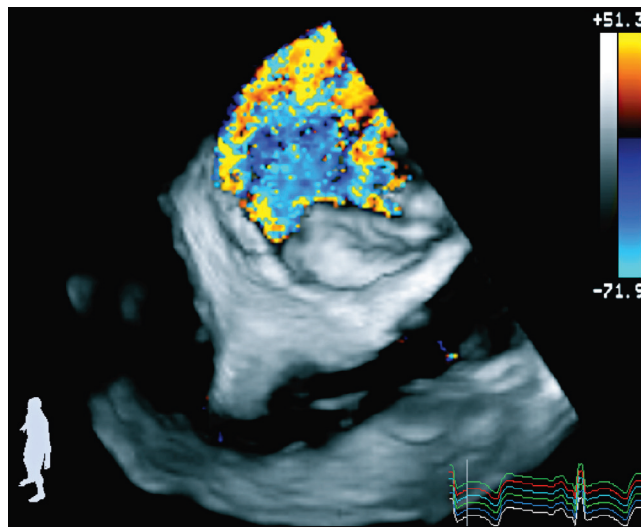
■ Three-dimensional color flow Doppler. Three-dimensional transesophageal echocardiographic image of a mitral regurgitation jet that extends throughout the coaptation line.
